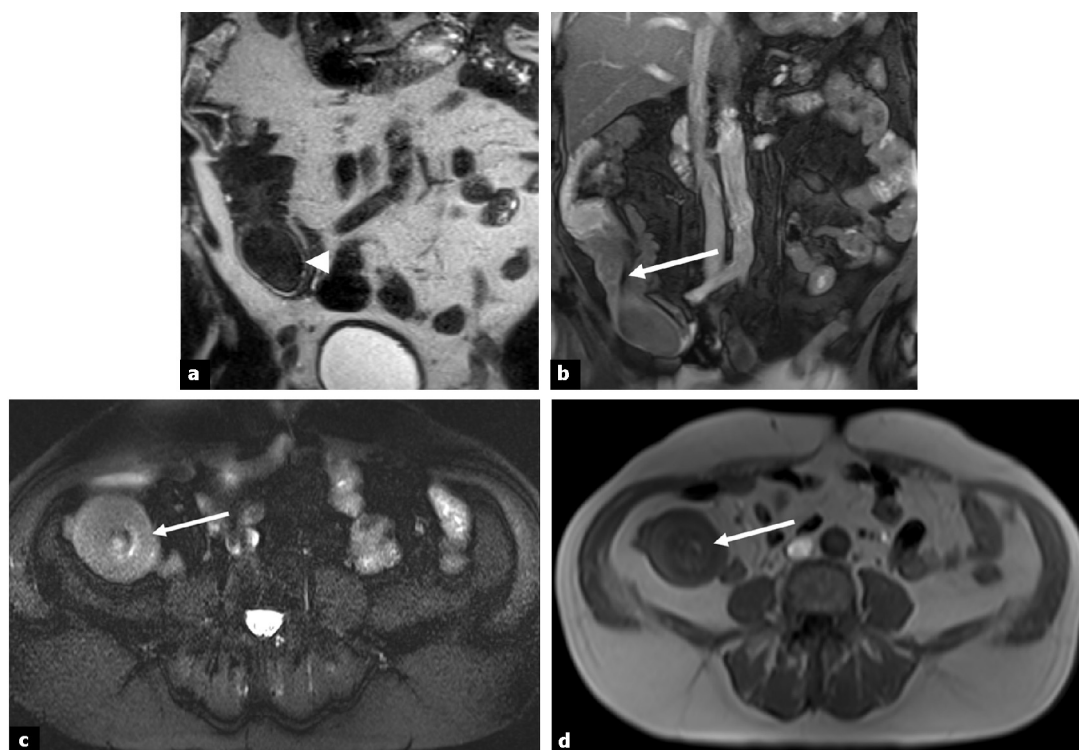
MRI slices showing the small bowel tumor (white arrowhead) complicated by an ileo-ileal intussusception (white arrow) (a: coronal T2-weighted HASTE [TR = 1000 ms, TE = 90 ms]; b: coronal T2-weighted TrueFISP Fat-Sat [TR = 3.2 ms, TE = 1.6 ms]; c: axial T2-weighted HASTE SPAIR [TR = 1180 ms, TE = 84 ms]; d: axial T1-weighted FLASH 2D in/out of phase [TR = 140 ms, TE = 4.8/2.4 ms]).
